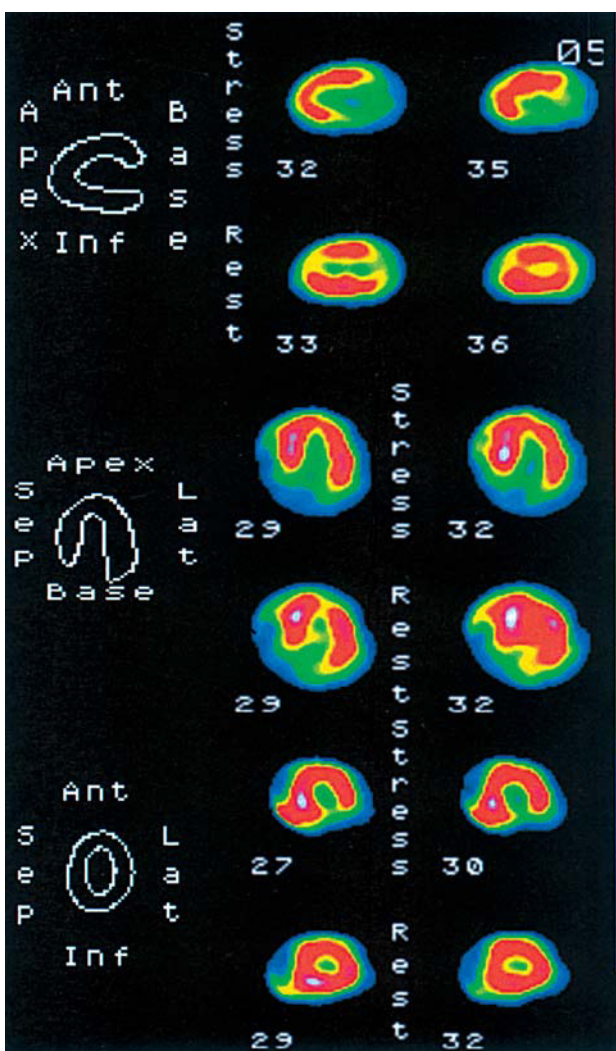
Single-photon emission computerized tomography (SPECT) of the heart using technetium-99.
